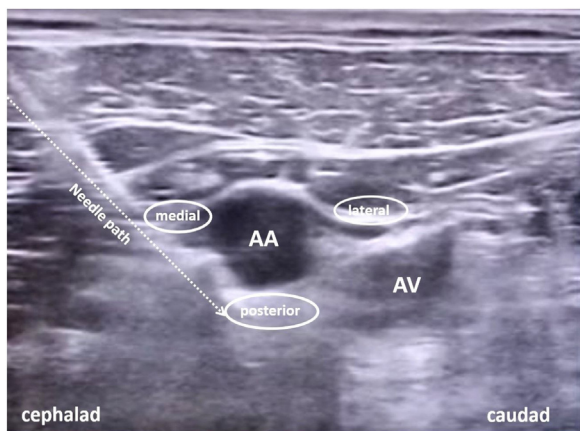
Sonogram showing local anesthetic injection points in infraclavicular block with a triple-injection technique. (AA, Axillary Artery; AV, Axillary Vein).
